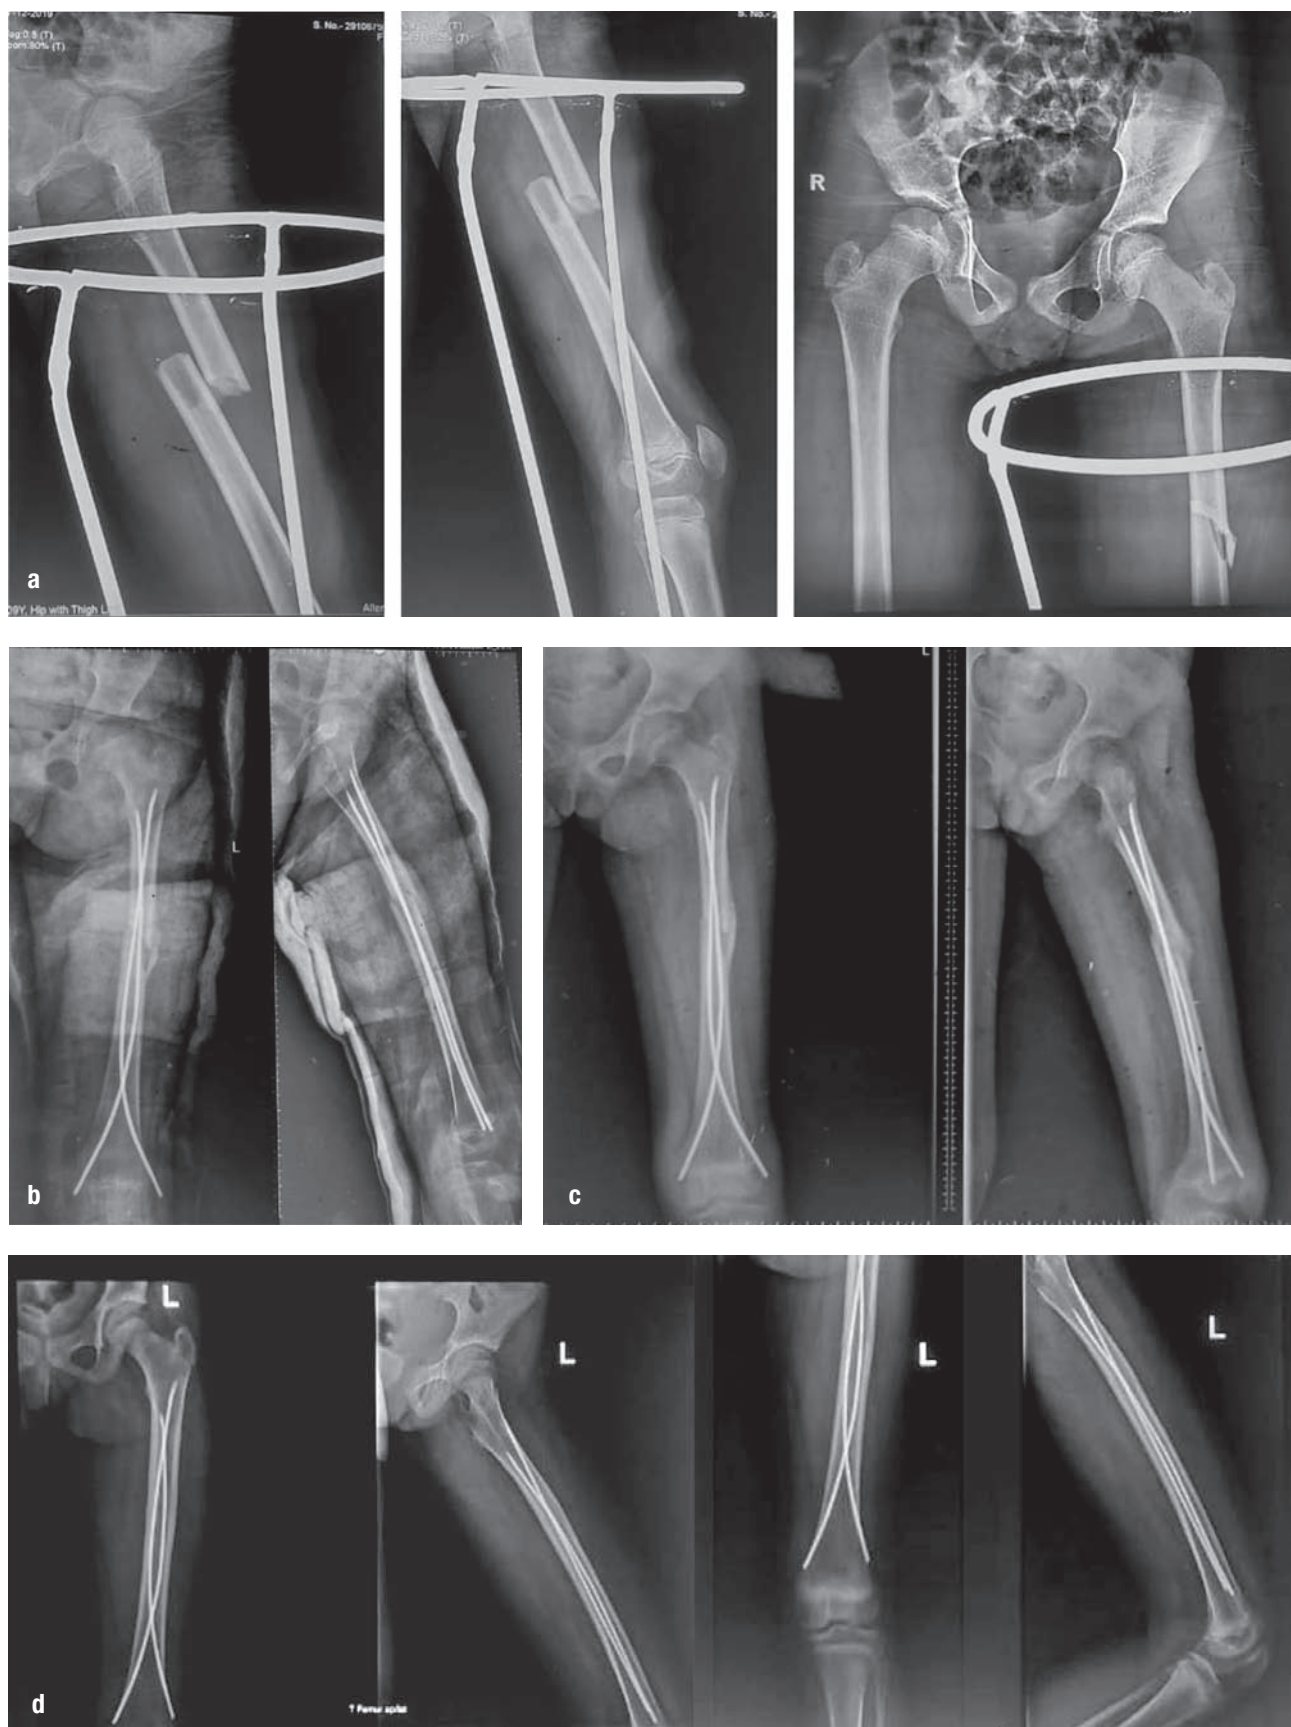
Case example. a – 12-year-old female presented with left side shaft of femur fracture; b – 2 weeks post-op radiographs; c – follow-up at 6 weeks; d – follow-up at 6 months.
